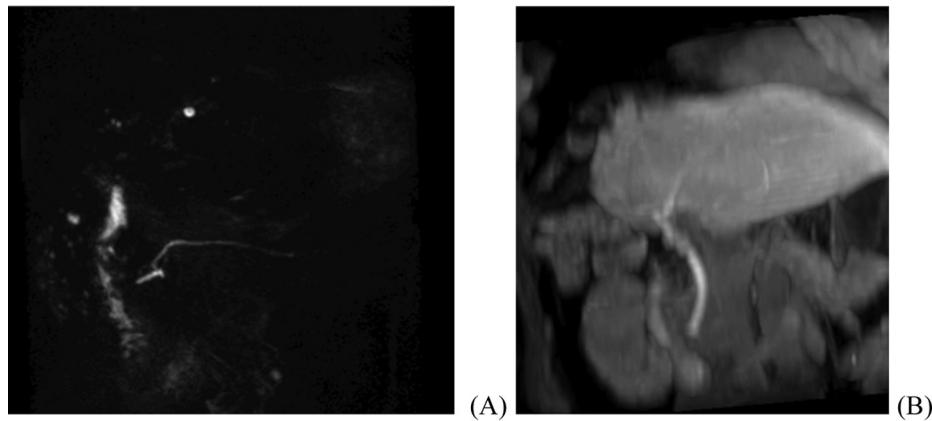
An 81-year-old man with liver cirrhosis underwent right hepatic lobectomy for hepatocellular carcinoma (Child–Pugh Classification A, MELD score 12, total bilirubin, 0.75 mg/dL). (A) T2W-MRC shows no visualization of any bile ducts but clearly depicts the pancreatic duct. Lack of visualization is probably due to thick bile in the biliary tree. (B) Gadoteric acid-enhanced MRC in the coronal plane demonstrates biliary enhancement of the common bile duct, common hepatic duct, and left hepatic duct (all ranked Grade 3). Both CE-MRC alone and combined CE/T2W-MRC provided sufficient visualization. CE-MRC = gadoteric acid-enhanced magnetic resonance cholangiography; MELD = model for end-stage liver disease; MRC = magnetic resonance cholangiography; T2W-MRC = T2-weighted magnetic resonance cholangiography.
